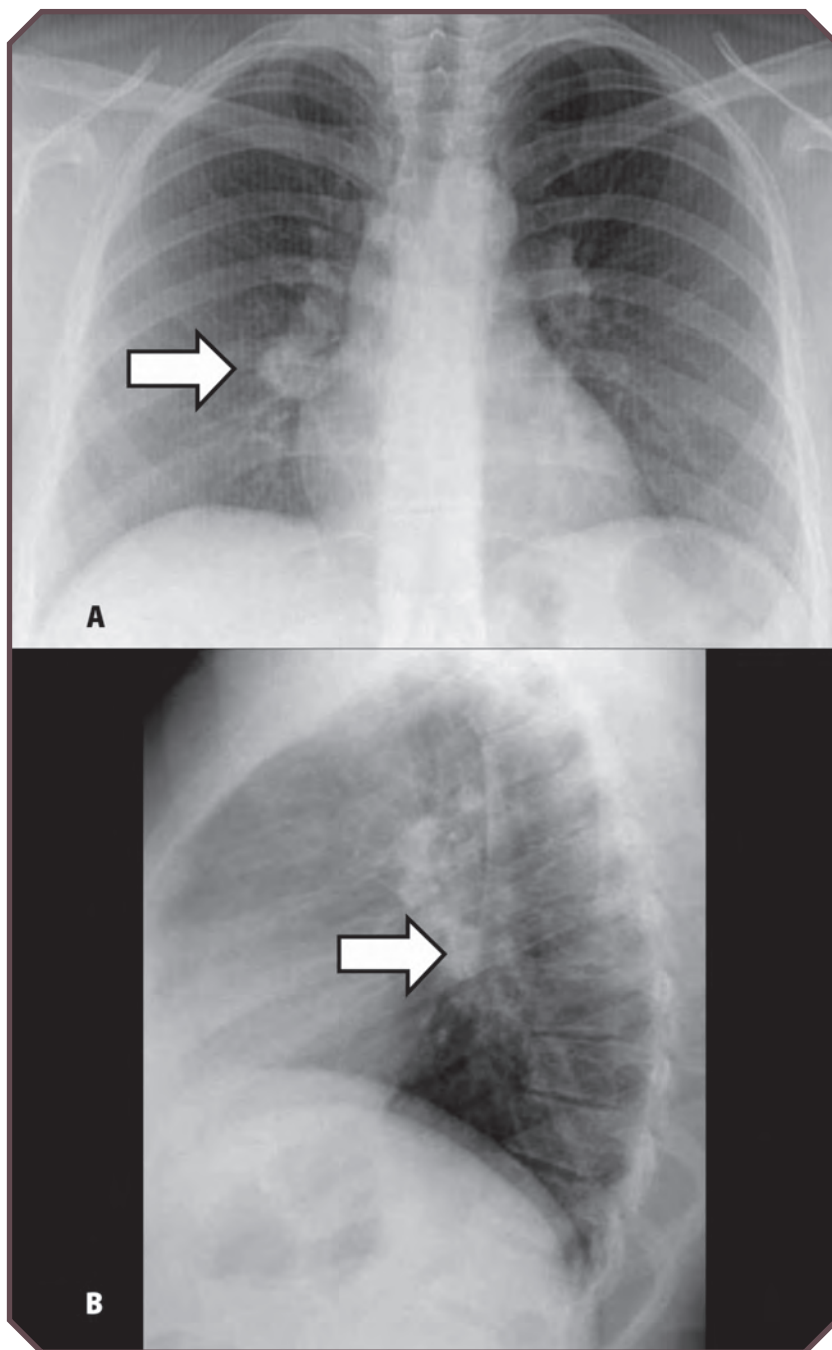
Histoplasmosis with calcified lymph nodes in a 14-year-old girl. A. Frontal and B. lateral radiographs show multiple, bilateral calcified hilar nodes (arrows).
